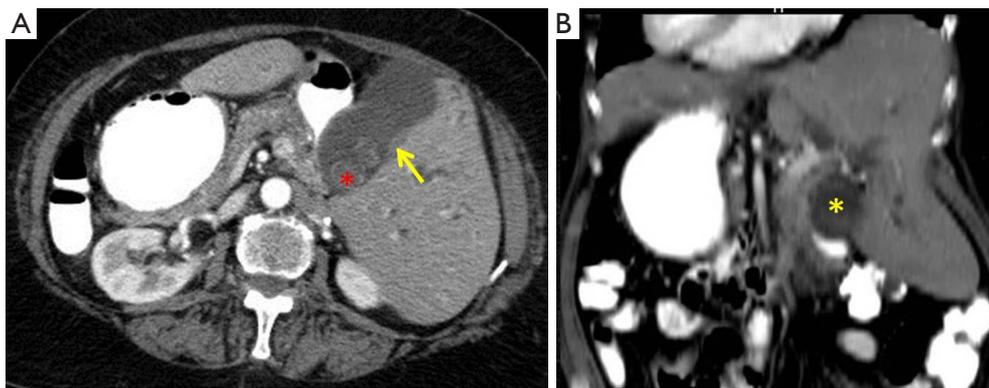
A 75-year-old female with situs inversus with carcinoma gallbladder. (A) Axial CT scan with contrast demonstrates left sided liver and right sided stomach. Focal gallbladder wall thickening (yellow arrow) with loss of plane of cleavage with the adjacent liver segment. Note multiple gall stones (red asterix); (B) coronal reconstruction CT images demonstrates left sided gallbladder (yellow asterix) with bilobar IHBRD. IHBRD, intrahepatic biliary radical dilatation.
